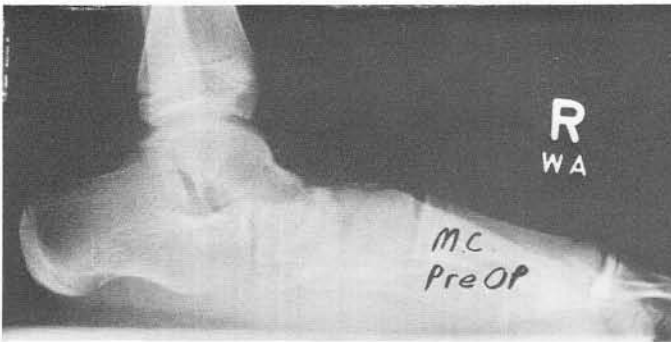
B. Lateral preoperative radiograph.
